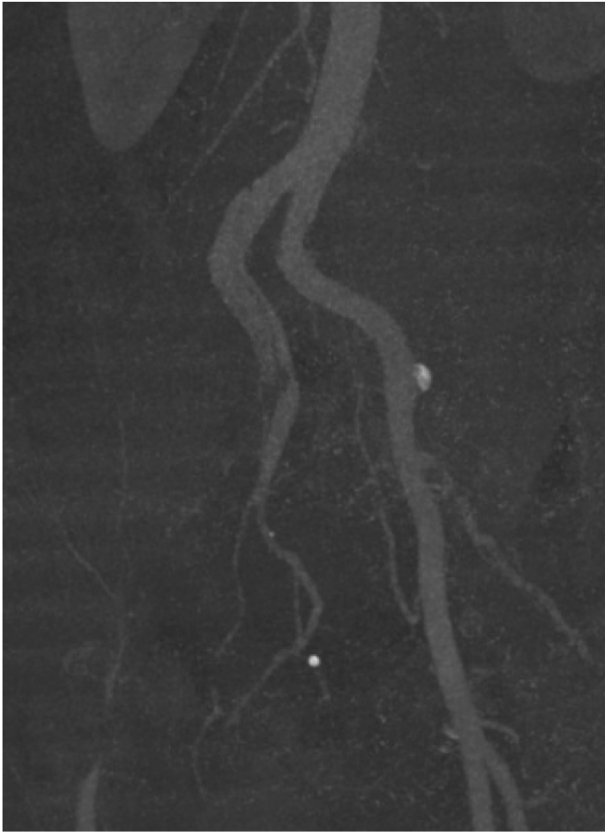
Computed tomography angiography of the dissected right common iliac artery with no blood flow in the external iliac artery, internal iliac artery and common femoral artery.
